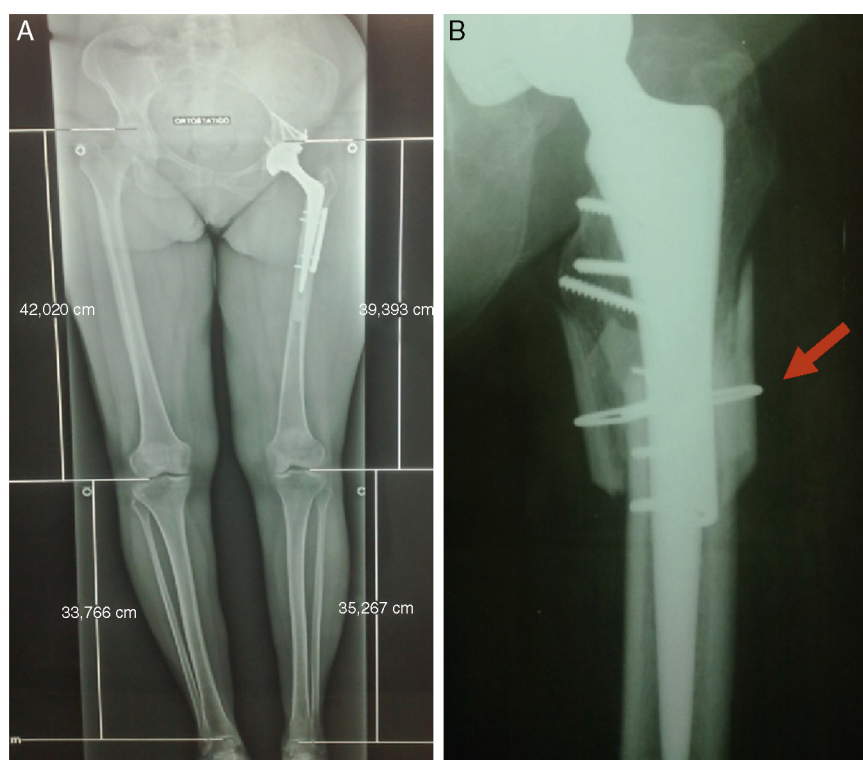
Radiographic control in the postoperative period of length discrepancy through orthoradiography of the lower limbs (A); X-ray showing autologous bone graft taken from the osteotomy fragment placed in the subtrochanteric region with cerclage by steel wire (arrow) (B).
